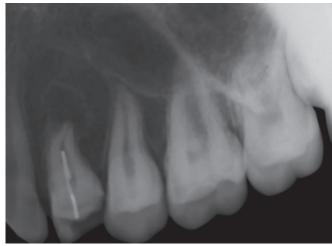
Preoperative intraoral periapical radiographic view of 24
